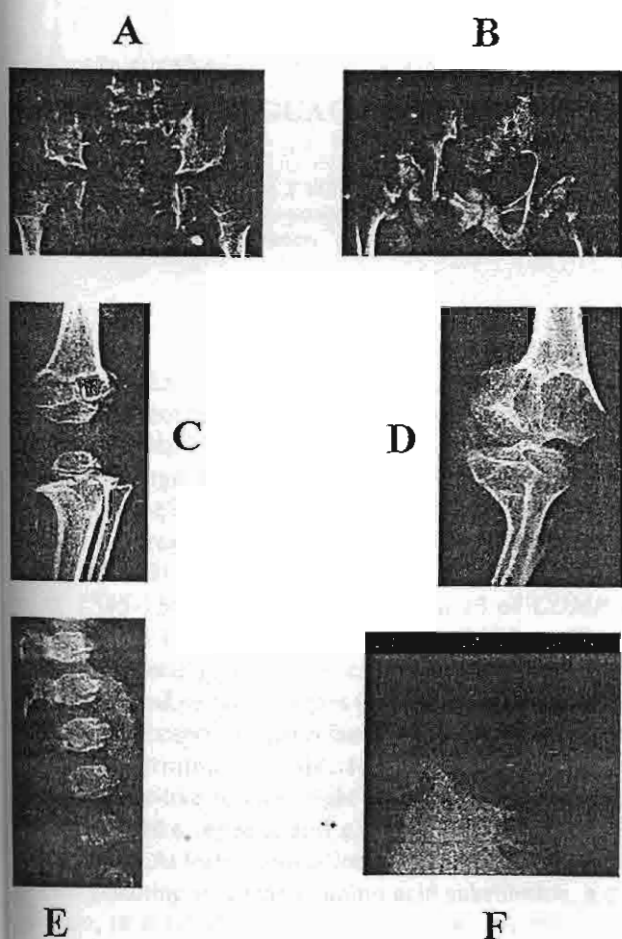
Radiographs of the patient (A, C, and E) and those of her father (B, D, and F). Hips (A and B): note that the acetabuli are irregular, the epiphyses (A) and the femoral heads (B) are small. Left knee (C and D): note the abnormal epiphysis and metaphysis in the child (C). Spine (E and F): note the flattened, bullet-shaped vertebrae (E) and the anterior wedging of L2 and the severe lordosis of the lumbosacral junction (F).
